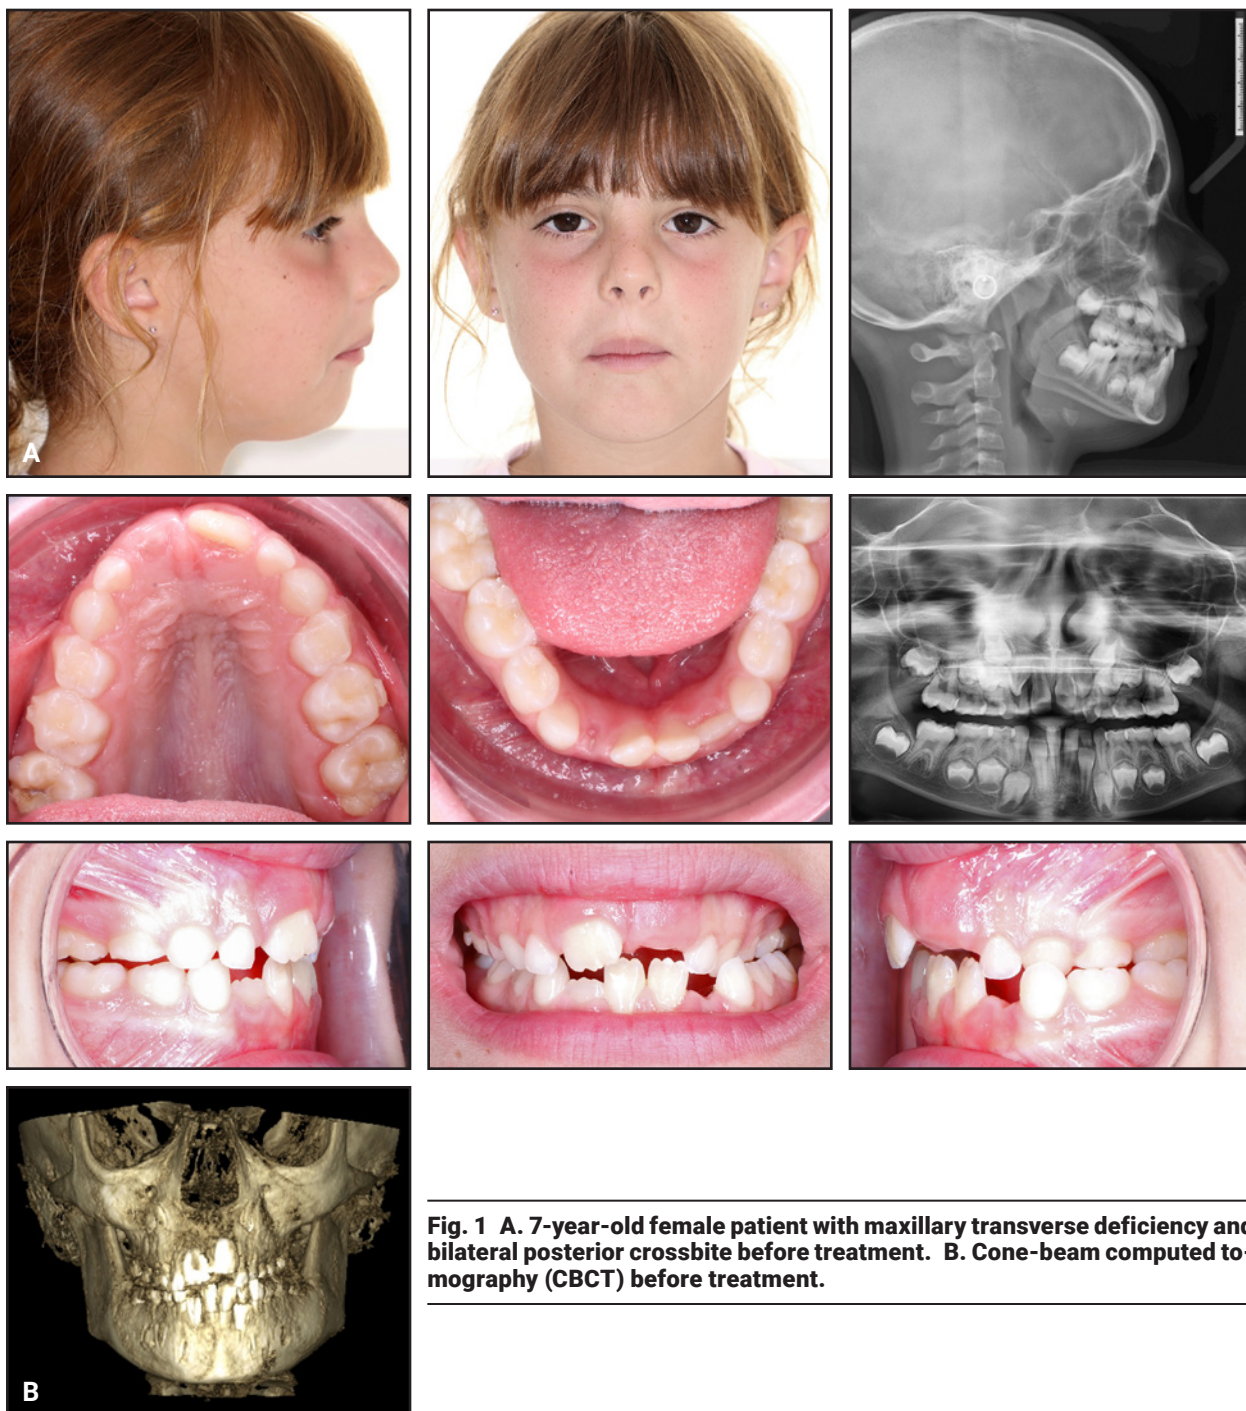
A. 7-year-old female patient with maxillary transverse deficiency and bilateral posterior crossbite before treatment. B. Cone-beam computed tomography (CBCT) before treatment.
